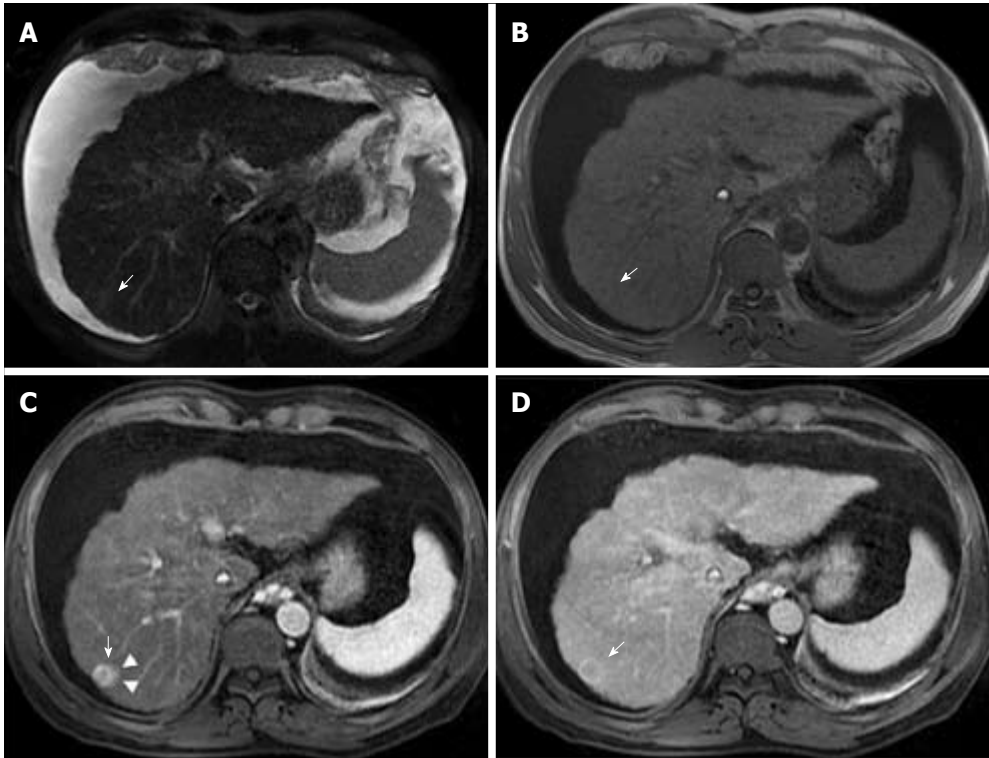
Small hepatocellular carcinoma in a patient with chronic liver disease and a previous left hepatectomy. Pre- (A) and post-contrast (gadoxetate disodium) fat-suppressed 3D-GRE T1-weighted images in the arterial (B), delayed (C) and hepatobiliary phases (D). A small HCC is shown in segment VIII displaying mild low T1 signal intensity (arrow, A), arterial hyper-enhancement (arrow, B) and no appreciable washout on the delayed phase (arrow, C). Low signal intensity is noted on the hepatobiliary phase (arrow, D). This example proves the benefit of hepatobiliary contrast agents in further characterization of liver nodules in the setting of chronic liver disease.
